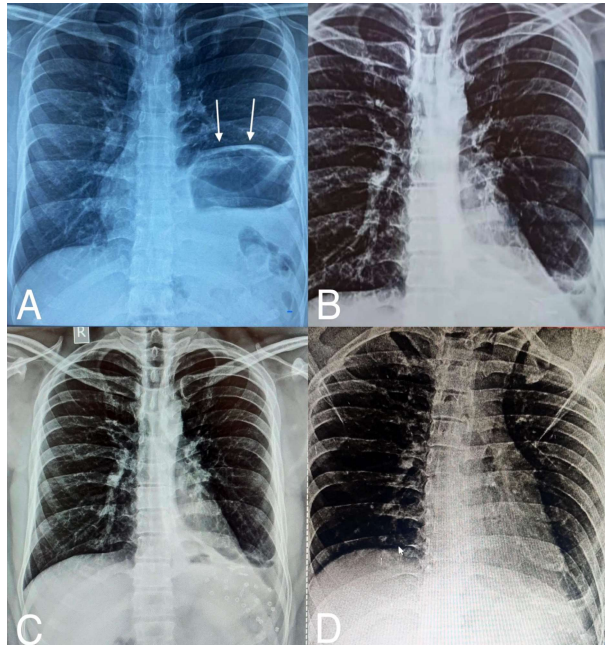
Serial X-ray Chest films. A) Preopfilm showing Lt BH (white arrows), B, C, D) 1, 3 & 5 months post-op films respectively, showing left costo-phrenic angle getting progressively clearer
